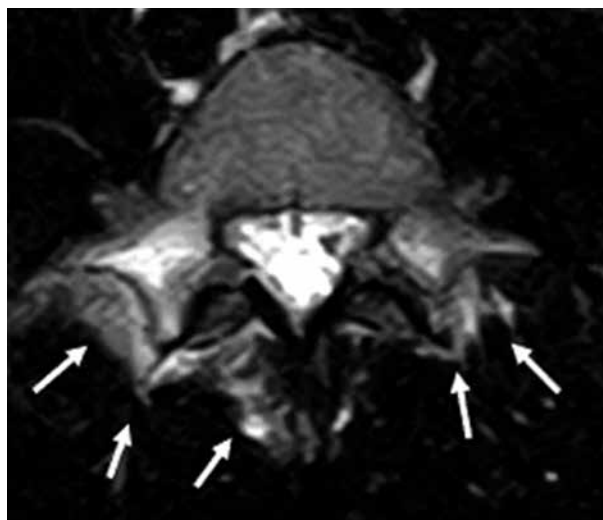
The presence of extrasosseous signal changes (ESCs) on MRI (arrow) has been identified in patients with spondylolysis.
